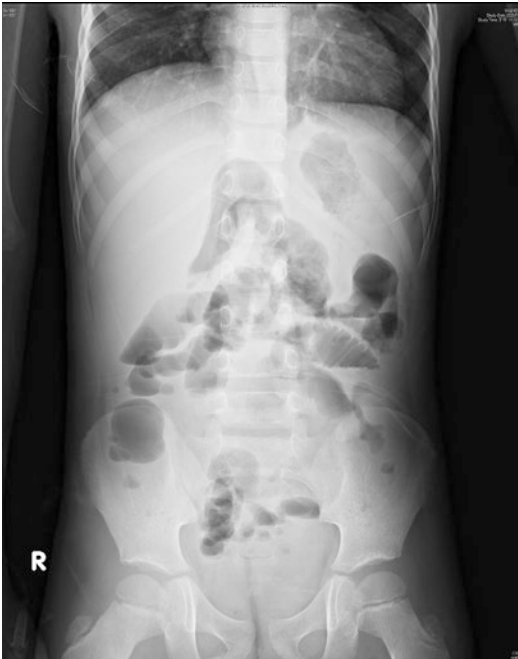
Few hours after insertion of rectal tube on the same day of arrival at the medical center, the distended colon on X-ray improved a lot
